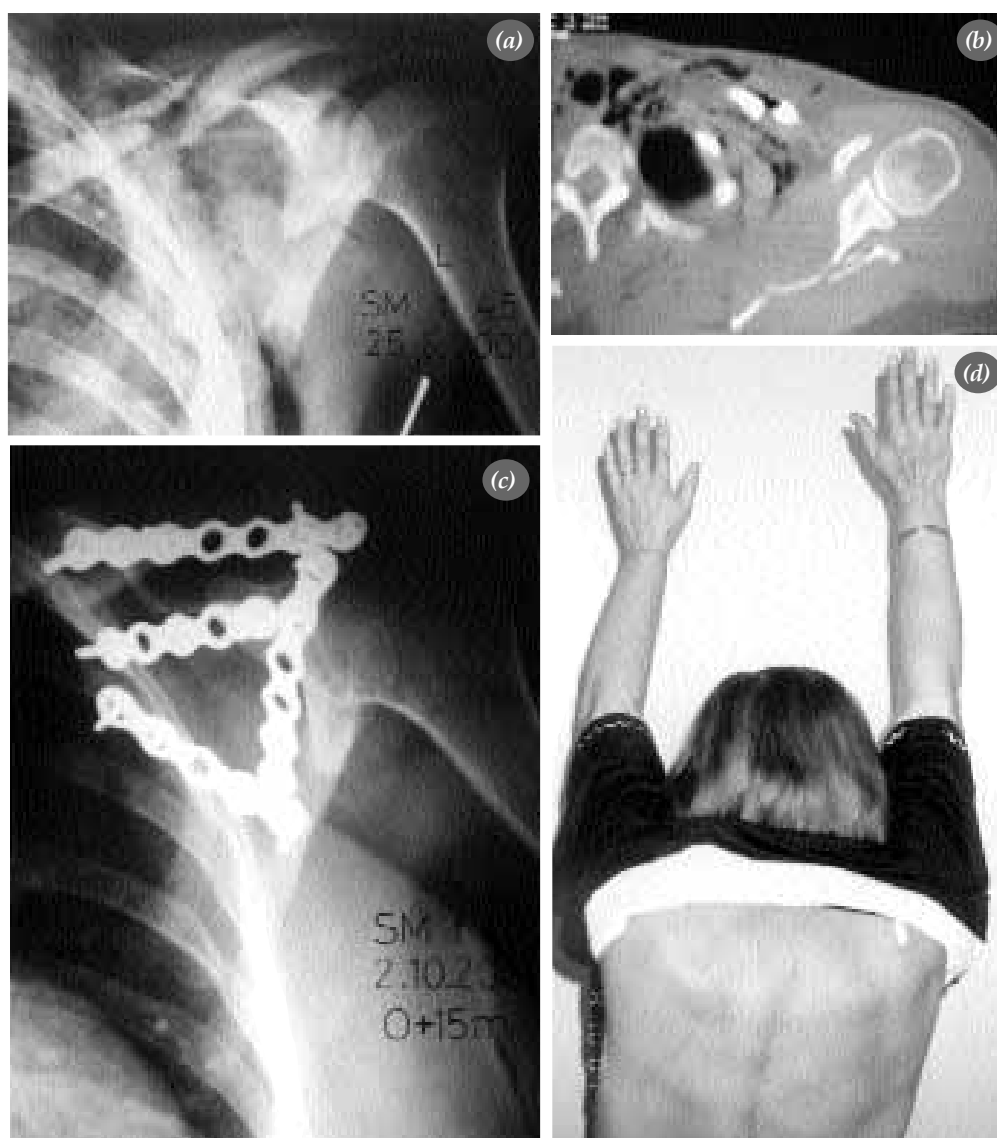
Left scapular neck and left clavicular fractures of the 45 year old female. There were T6 vertebral burst fracture, sternal fracture, ipsilateral serial costal fractures and hemothorax as additional injuries. Preoperative (a) anterior-posterior graphy and (b) CT cross section (c) anterior-posterior graphy and (d) clinical view of anterior elevation/flexion of shoulder in follow-up.
